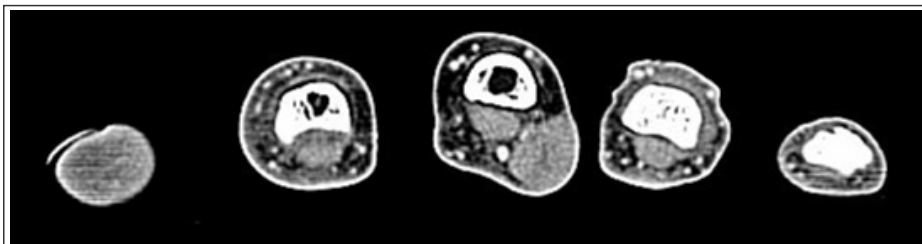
Axial cut of computed tomography scan demonstrating mass in the long finger.
